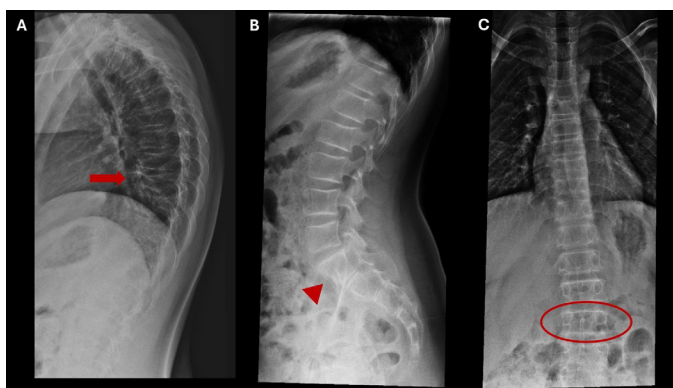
Lateral radiograph (A and B) of the thoracolumbar spine following four doses of zoledronic acid in Patient 2, showing improved bone mineral density and partial restoration of T9 vertebral body height. Diffuse sclerotic lines are observed across multiple vertebral bodies (arrow), consistent with increased bone remodeling activity. Vertebral body contours are well defined, and no new fractures are evident. (C) Anteroposterior radiograph of the spine shows reduction of the previously observed scoliotic curvature
